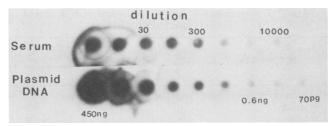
Autoradiogram after dot blot hybridization of plasmid pSB321 and serum containing B19 virus. Serum and plasmid were diluted in 2× SSC, and 10 μ l of each dilution was denatured and filtered over nitrocellulose. For the serum the fold dilution is indicated above three of the dots, and for the plasmid the quantity of DNA on each dot is indicated below three of the dots. ³²P-labeled pSP321 was the probe, and the nitrocellulose sheet was exposed to X-ray film for 1 week at -70° C.
